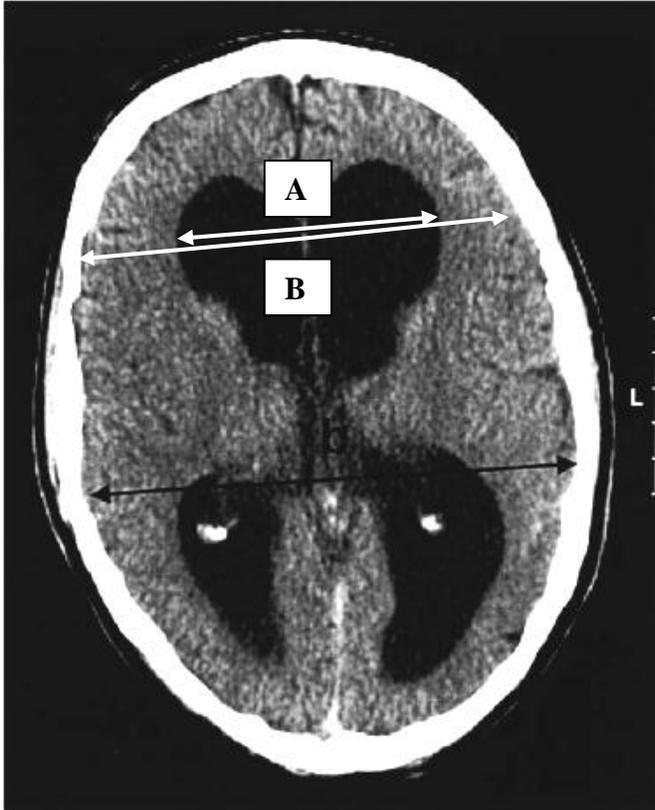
CT scan showing the calculation of Evans' index
